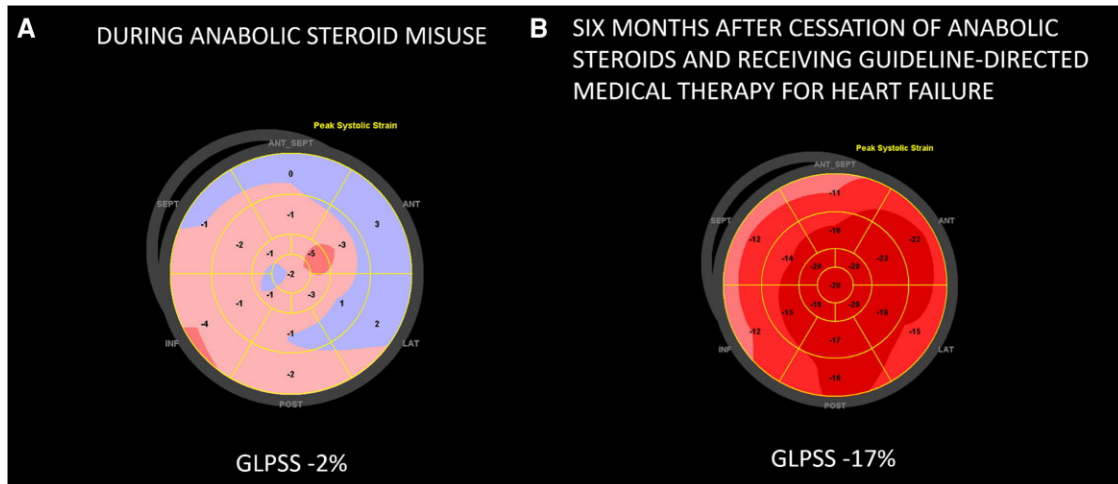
Echocardiographic strain images. (A) During anabolic steroid misuse and (B) 6 months after cessation and with the guideline-directed medical therapy. GLPSS, global longitudinal peak systolic strain, normal value -18% to -22% .
